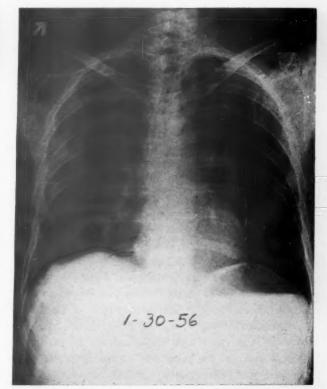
Case II Chest roentgenogram taken on January 30, 1956 showing marked clearing of the diffuse bilateral densities.
